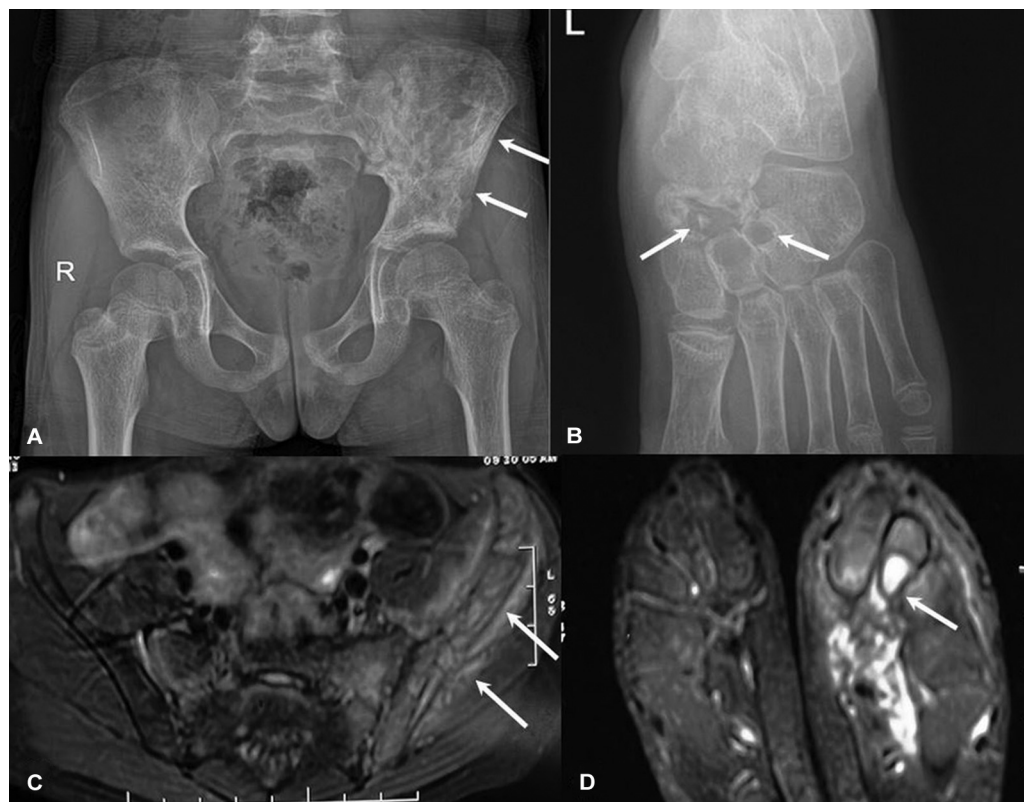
Differential diagnoses: Tubercular osteomyelitis. Frontal radiograph of pelvis (A) demonstrates an irregular lytic sclerotic lesion in left iliac wing (arrows, A). Left foot radiograph shows multiple well-defined clustered lytic lesions in the navicular, middle, and lateral cuneiforms (arrows, B). Axial fat-suppressed T2-weighted images at level of pelvis (C) demonstrates hyperintense marrow signal in left iliac wing with adjacent inflammatory changes extending into the soft tissues (arrows, C). Axial fat-suppressed T2-weighted images at level of foot (D) shows marrow alteration within the tarsal bones with a well-defined intraosseous cyst-like lesion within the middle cuneiform, indicating an abscess (arrow, D).
